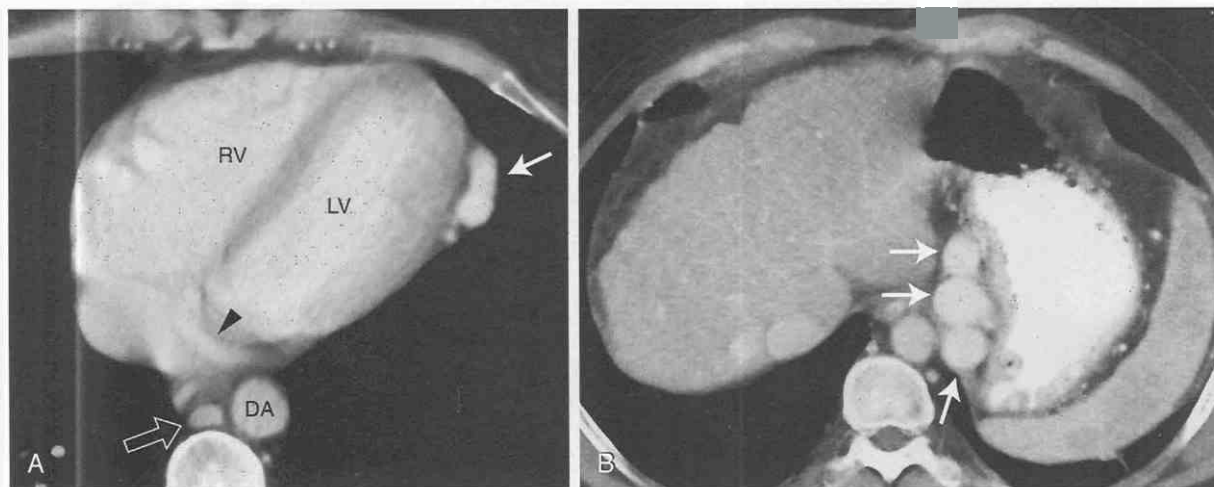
Enlarged pericardiophrenic vein. A, Axial CT with intravenous contrast medium shows marked distention of the pericardiophrenic vein (arrow). DA, descending aorta; LV, left ventricle; RV, right ventricle. The open arrow points to the azygos vein, and the arrowhead to the coronary sinus. B, More caudal image demonstrates gastric varices (arrows) as the cause of the distention of the pericardiophrenic vein.
